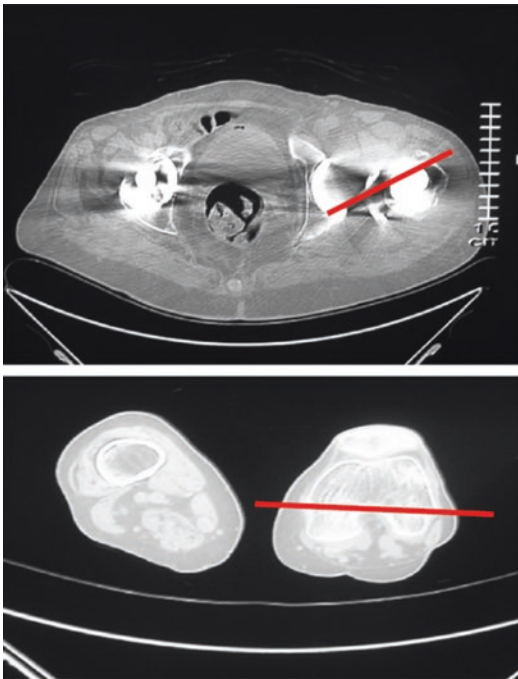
Combined CT scan of the femoral neck and ipsilateral trans-epicondylar axis for determining femoral component anteversion. It demonstrates retroversion of the femoral prosthesis. Wera GD, Ting NT, Moric M, Sporer SM, Jacobs JJ, Paprosky WG, Della Valle CJ. The Causes and Management of Hip Instability: An algorithmic approach. *Seminars in Arthroplasty* 2015;26(3):131–135. *Reproduced with permission from Elsevier Ltd.*
